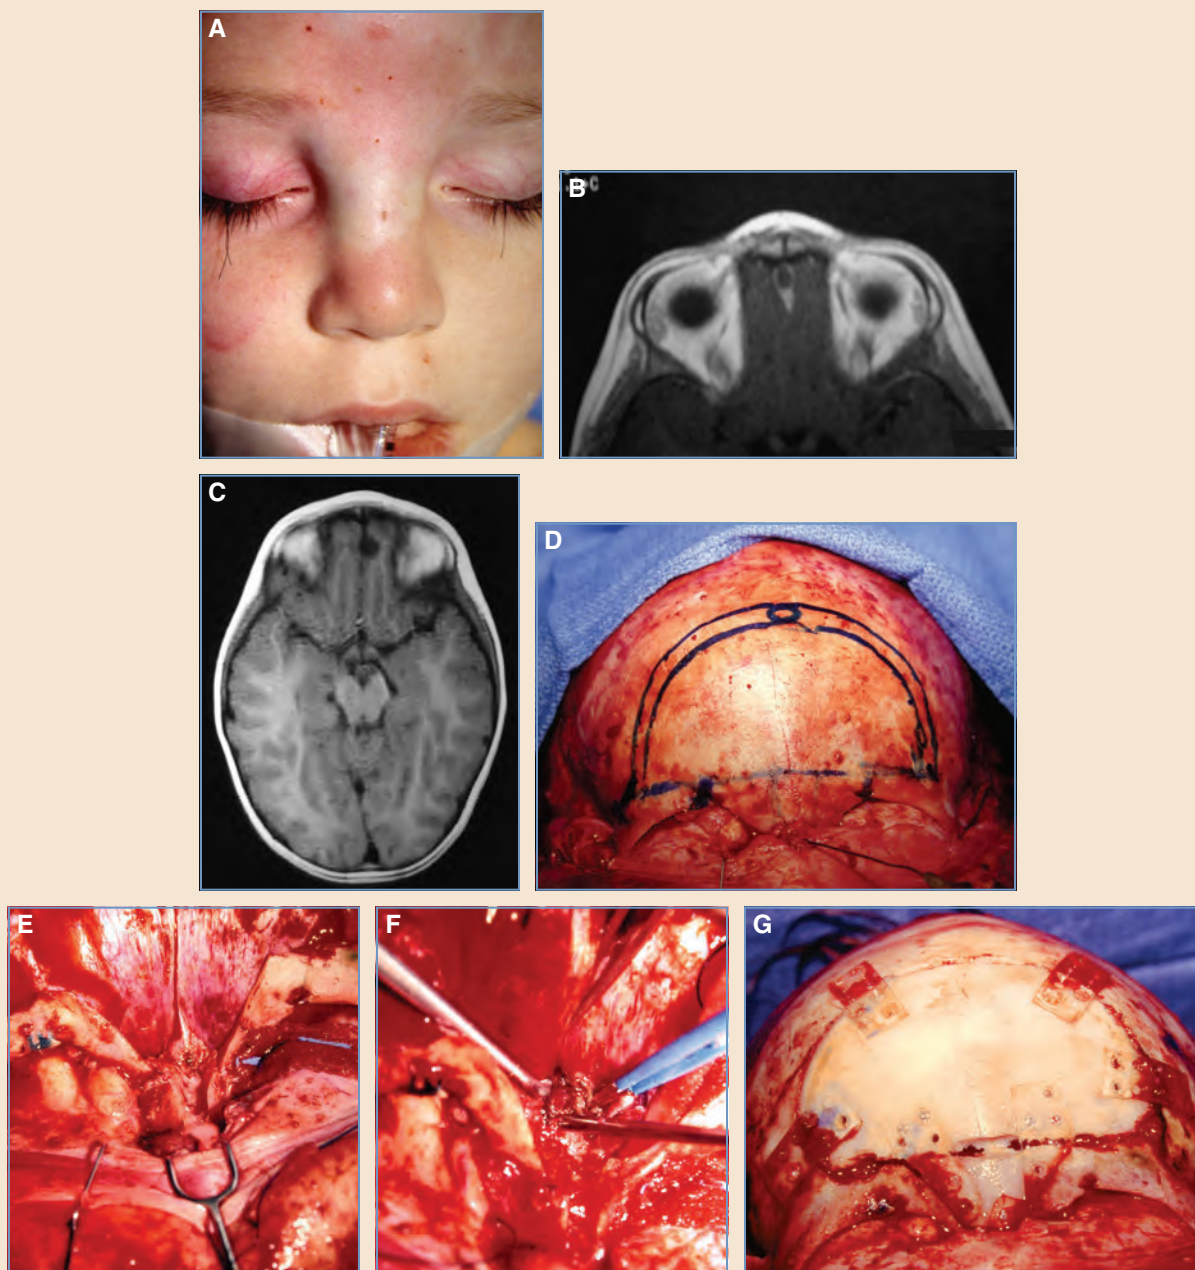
A, This unusual dermal cyst and sinus extended not only intracranially but also intraparenchymally (into the frontal lobe). A small hair can be seen protruding from the sinus opening. B, MRI showing a cup-shaped defect in the crista galli. C, Intraparenchymal location of the cyst in another axial view. D, The “keyhole” frontal craniotomy is outlined, along with the planned osteotomy line for removing the frontonasal complex en bloc. E and F, Excellent views of the area between the falx cerebri, which provides access for resecting the portion of the dermoid within the frontal lobe. G, The frontonasal bony complex and frontal bone are replaced and fixed with absorbable plates.
